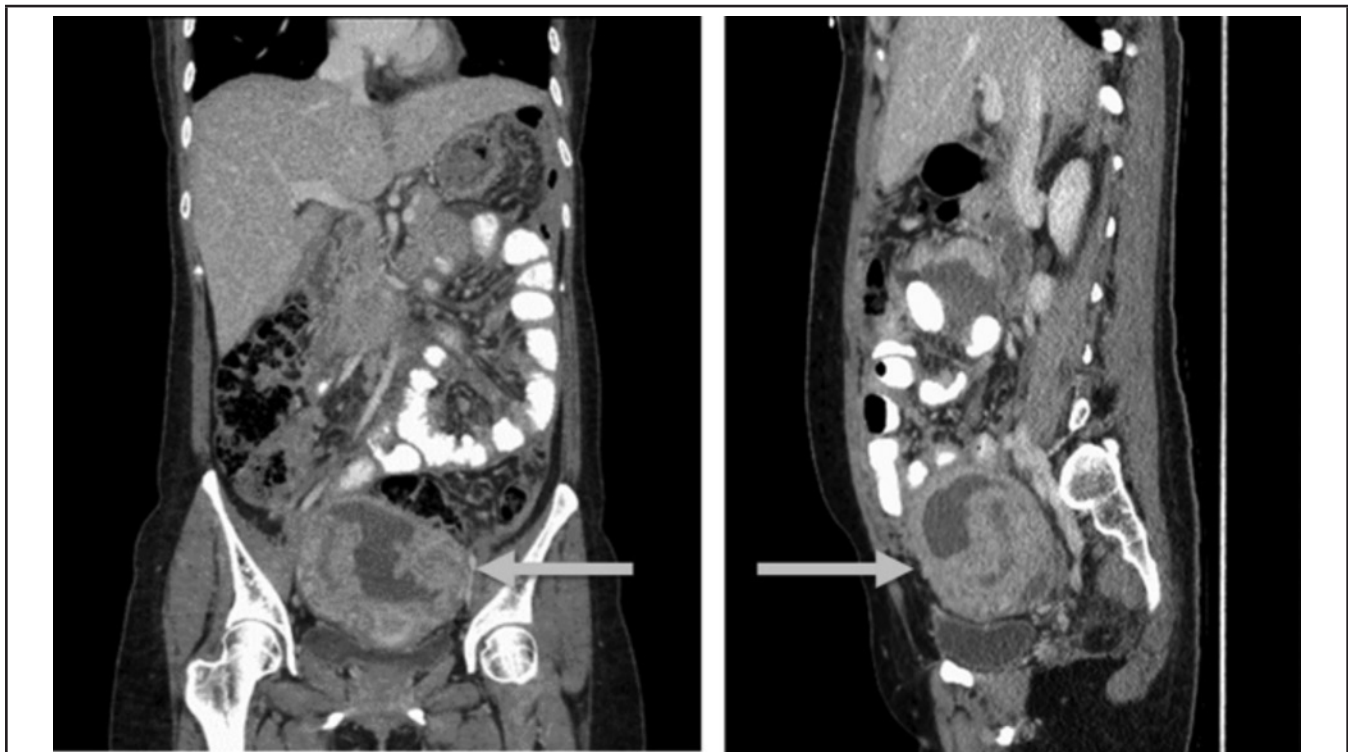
On CT scan, a 14 cm complex cystic/solid pelvic mass (as indicated by arrow) concerning for ovarian cancer was seen. Enlarged epicardial and parasternal lymph nodes were also noted; no parenchymal lung lesions were present. The findings were suspicious for advanced ovarian cancer.
